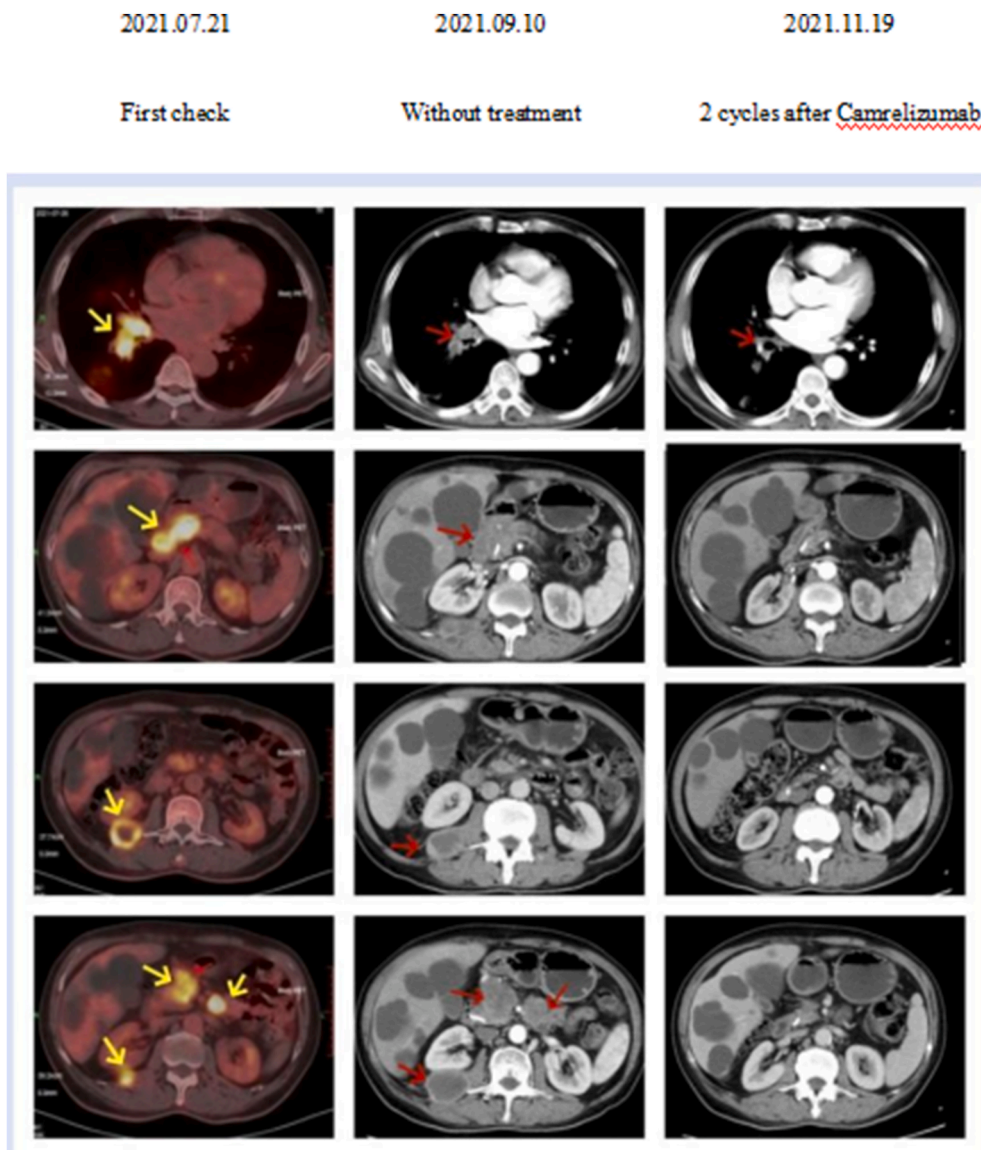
Computed tomography (CT) scan shows changes in metastatic lesions after camrelizumab.
